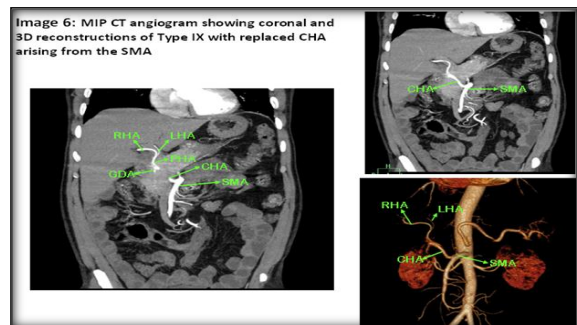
MIP CT angiogram showing coronal and 3D reconstructions of Type IX with replaced CHA arising from the SMA
